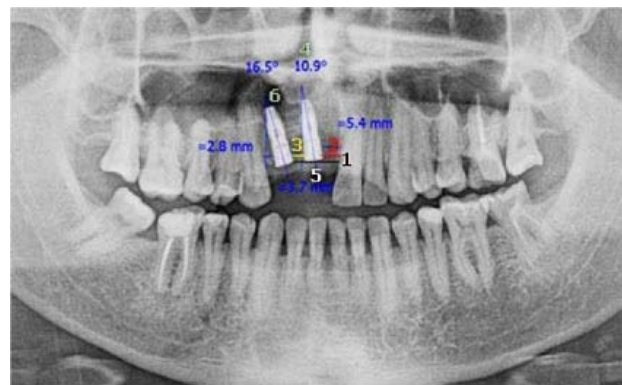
Description of the measurements taken for the characterization of the implants in the panoramic radiographs. Note: 1: location according to alveolar bone crest; 2: distance to contiguous tooth; 3: distance to contiguous implant; 4: angulation with respect to midline; 5: presence or absence of prosthetic crown; 6: presence or absence of peri-implant lesion.
